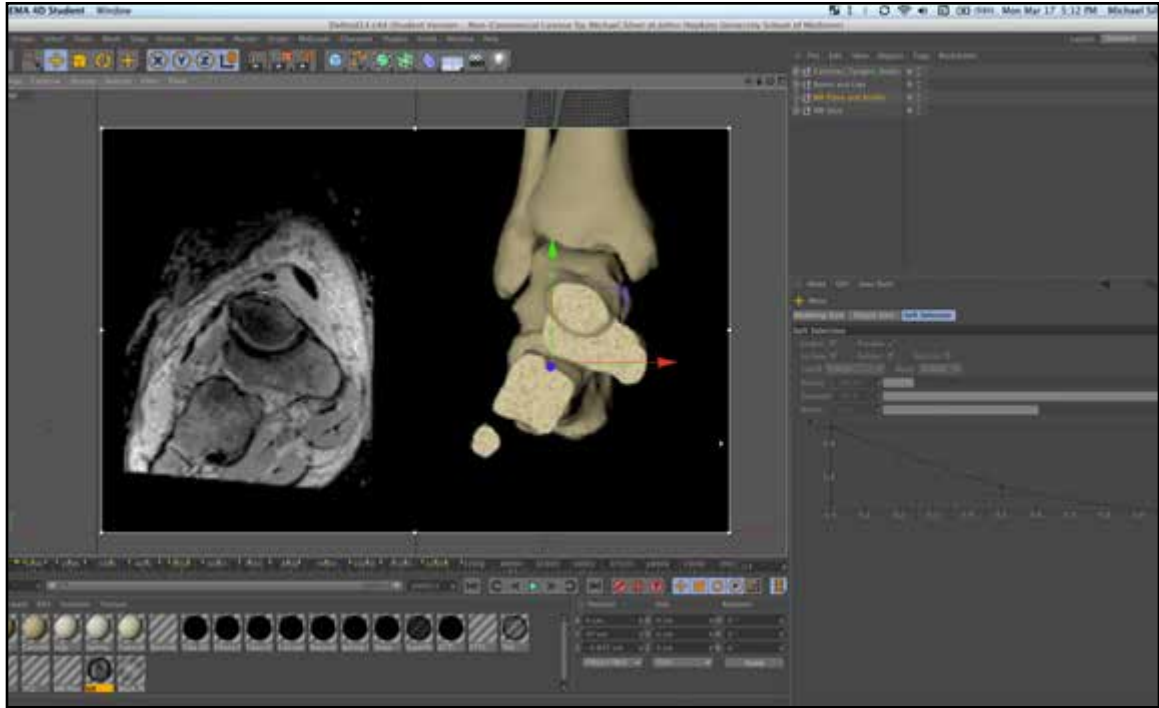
Locating correct model section location for MR image.
